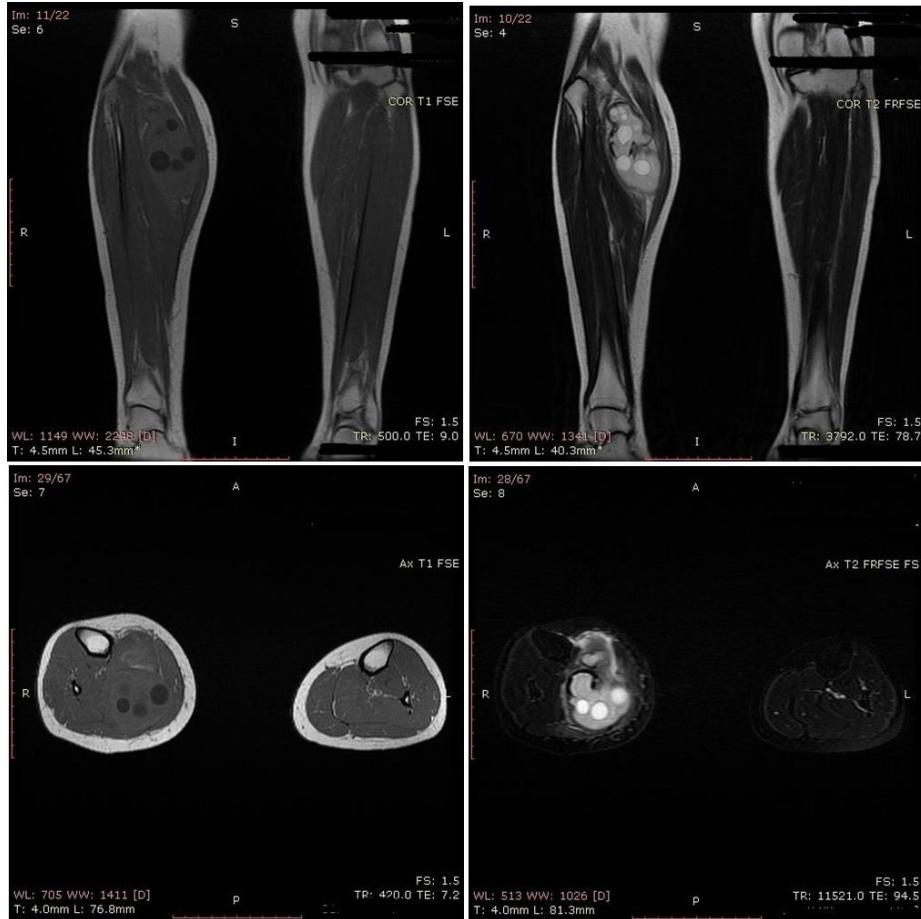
MRI showing a cystic formation with low signal on T1 and high signal on T2 sequence. Multiple secondary cystic formations are found inside the lesion.
